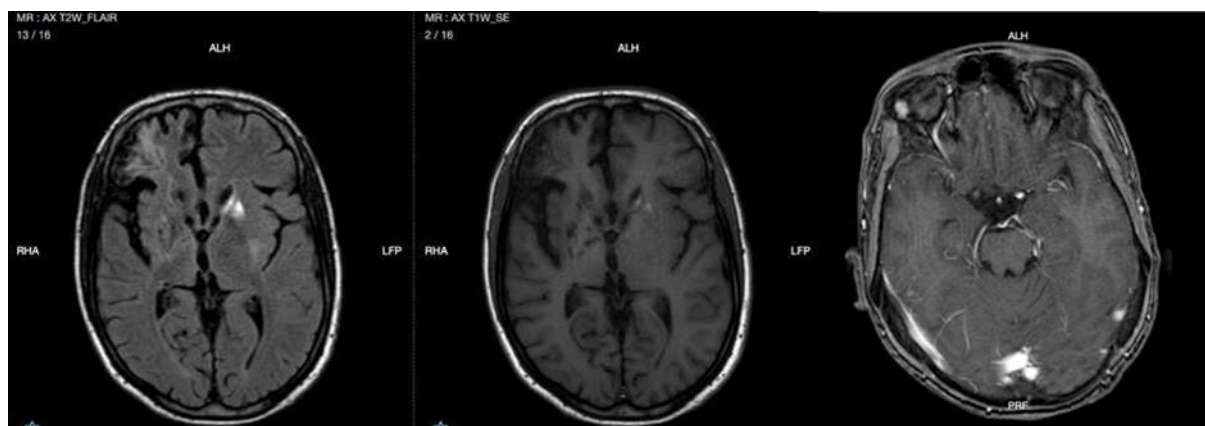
Contrast-Enhanced Brain MRI
